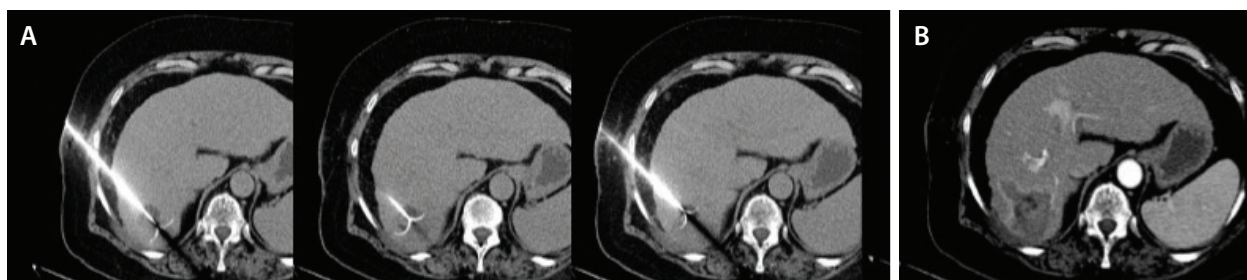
RFA of HCC involving the right lobe of the liver creating overlapping spheres (A). Final contrast-enhanced CT image postablation demonstrated the ablation zone and tract ablation (B).
